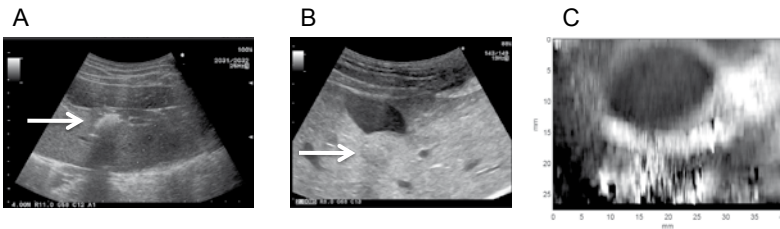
(A) B-mode ultrasound image of freshly implanted pseudotumor, directly post-implantation (B) Bmode ultrasound image of established pseudotumor, day 7 (C) Ultrasound elasticity image of pseudotumor.
